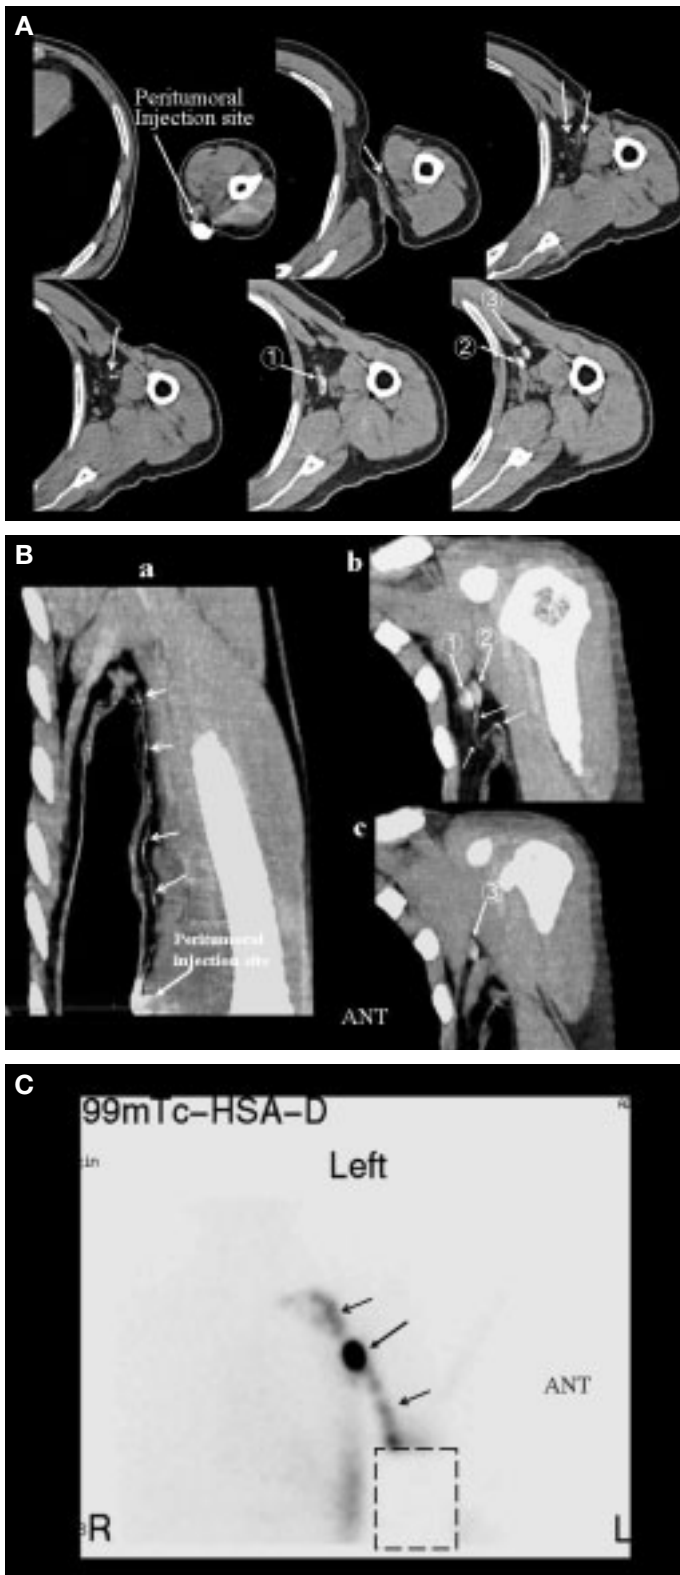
Transaxial images (A) and MPR (B) MDCT-LG images, and Tc-99m-HAS lymphoscintigraphy (C) in a 65-year-old male with melanoma in the left forearm (Patient No. 5 in Table 1).
